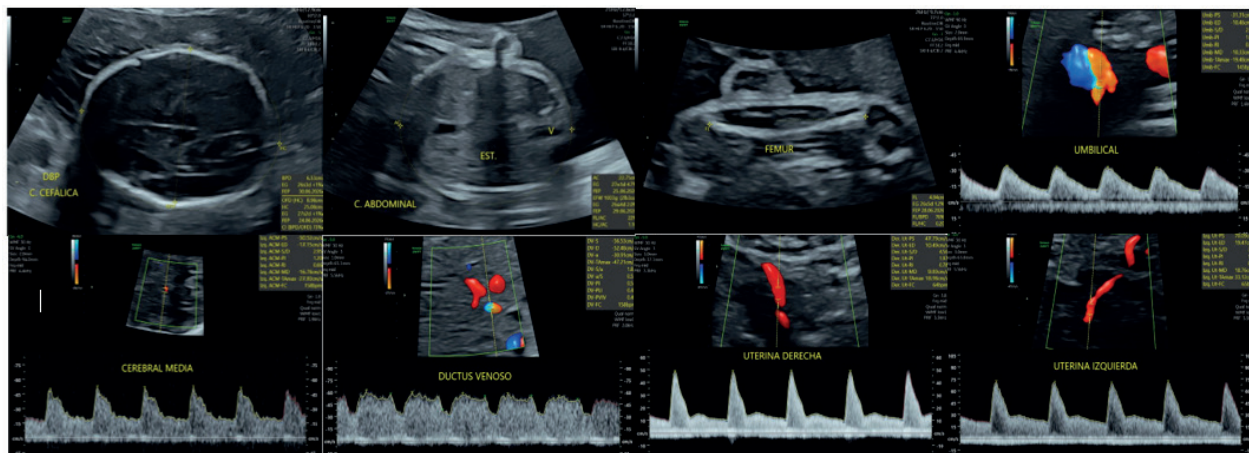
Obstetric ultrasound at admission A) Biparietal diameter (BPD): 65 mm. B) Abdominal circumference (AC): 227 mm. C) Femur length (FL): 49 mm. D) Umbilical artery pulsatility index (PI): 1.07 (48th percentile). E) Middle cerebral artery PI: 1.20 (1st percentile). F) Ductus venosus PI: 0.54 (43rd percentile). G) Right uterine artery PI: 1.97. H) Left uterine artery PI: 1.53. Mean uterine artery PI: 1.75 (>99th percentile).
